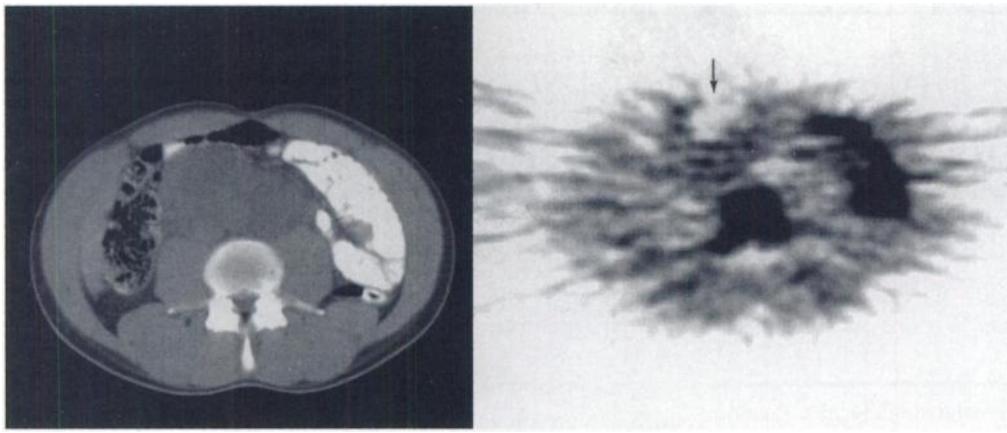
Abdominal CT and PET images of Patient 10. The CT scan shows a retroperitoneal tumor mass in which cystic or necrotic parts are visible. With PET, decreased tyrosine uptake is seen at the location of the largest cystic portion.
